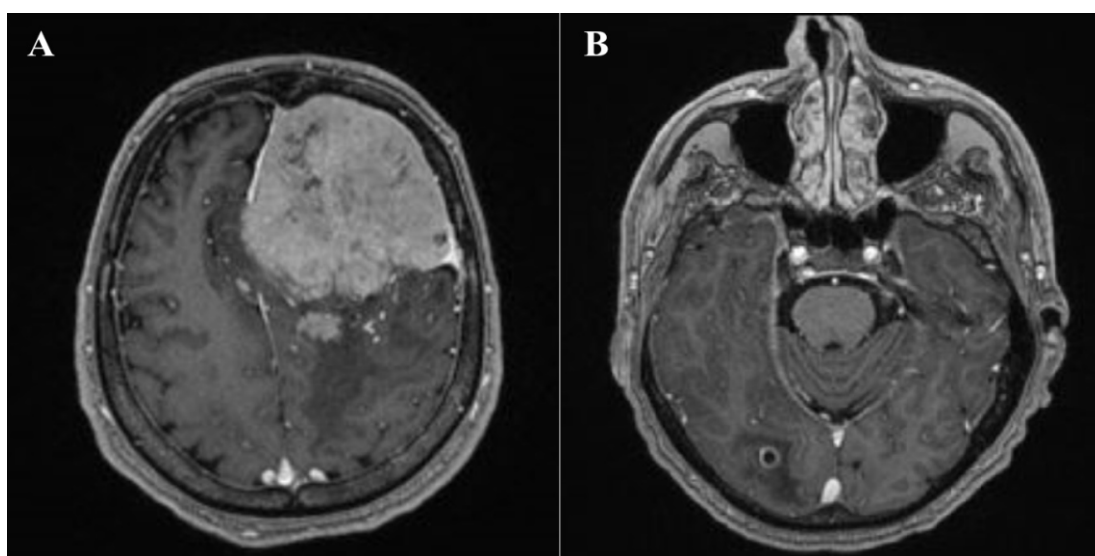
Pre-operative MRI of the giant Meningioma: A) Axial T2 weighted MRI with contrast of the giant meningioma in the right frontal lobe showing mass effect and midline shift; B) Axial T2 weighted MRI with contrast showing a small ring enhancing lesion in the right parieto-occipital lobe.
